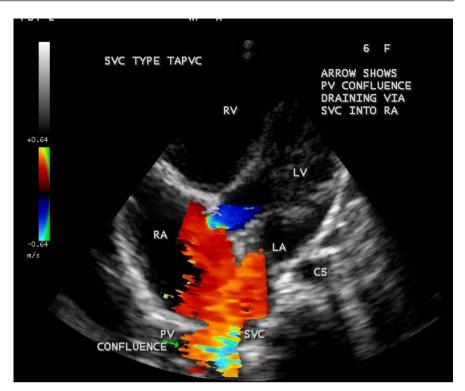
Color flow imaging showing the SVC (superior vena cava) type total anomalous pulmonary venous connection (TAPVC) in a 6-year old girl in apical four chamber view.
